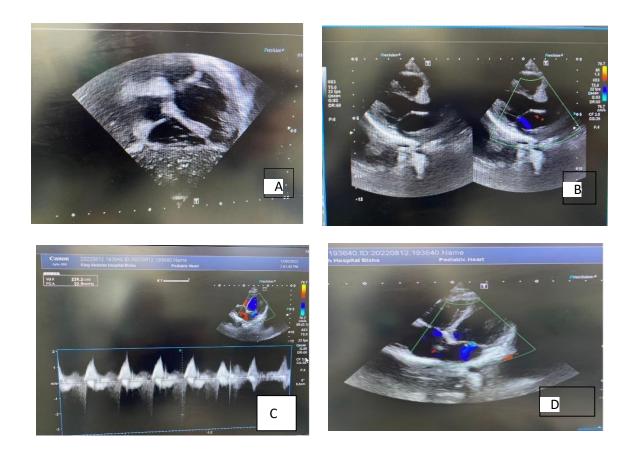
A) Subcostal view B) Long axis parasternal view C) Mitral valve regurgitation Doppler D) 4 chambers view. All show LV dilatation, mitral regurgitation.
